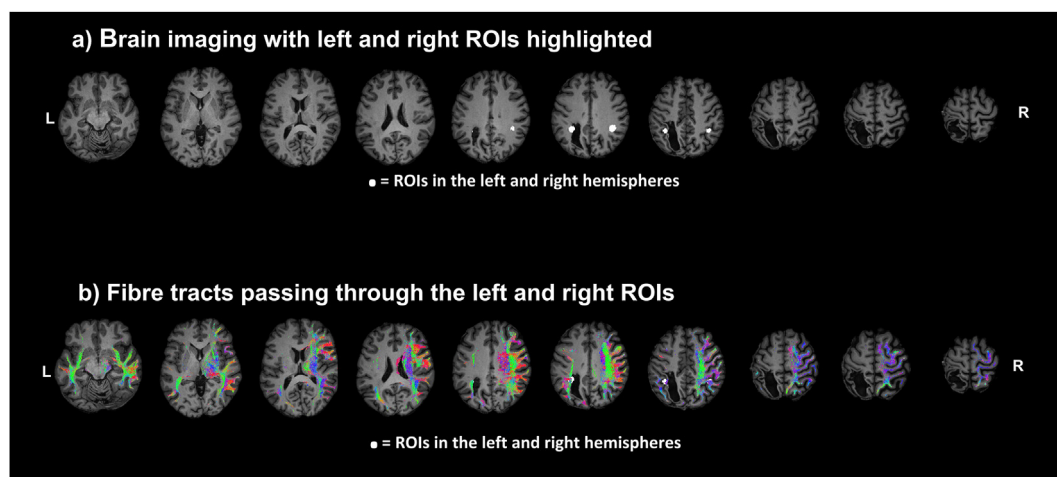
Panel a: The patient's brain images showing the lesion in the patient's MRI space. The ROIs are plotted in white, within the left and the right hemispheres. ROIs were drawn around the site defined by Rusconi et al. (2009) in the left hemisphere (MNI coordinate: $-35, -41, 34$) and around a homologous site in the right hemisphere (MNI coordinate: $35, -41, 34$). This procedure is described in detail in Section 2.2.3. Panel b: Reconstruction of white matter crossing the defined ROIs within the left and right hemispheres (see Section 2.2.3 for details; see also Fig. 3b). Note that we masked the corpus callosum to allow a cross-hemispheric comparison. However, because of this masking procedure, streamlines across hemispheres were not tracked.
